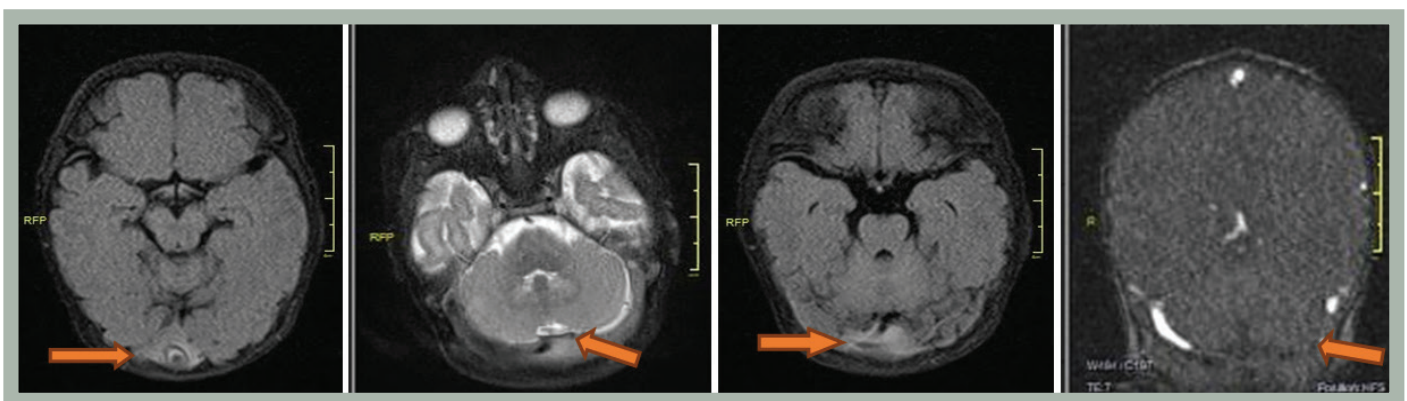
Cranial magnetic resonance imaging. Loss of signal void and non-visualisation of the left sagittal sinus indicate thrombosis of the superior sagittal sinus. A filling defect is seen in the left transverse sinus
